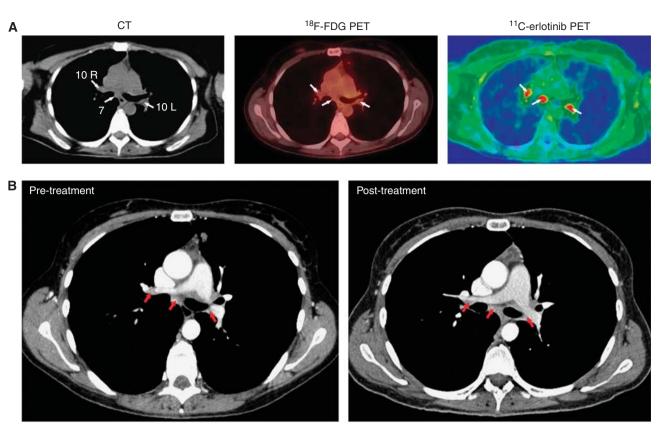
¹¹C-erlotinib accumulation in lymph nodes that were negative on ¹⁸F-FDG PET/CT in a 42-year-old patient (no. 6). (A) Left: transaxial slices of contrast-enhanced CT; middle: ¹⁸F-FDG PET/low-dose CT; right: ¹¹C-erlotinib PET/low-dose CT. CT (left figure) showed an enlarged lymph node (> 10 mm) at position 7 (arrow) and non-enlarged lymph nodes (< 10 mm) at positions 10R and 10L (arrows). None of these lymph nodes were visualized by ¹⁸F-FDG PET/CT (arrows, middle figure), whereas both enlarged and non-enlarged lymph nodes were visualized by ¹¹C-erlotinib PET/CT (arrows, right figure). The ratio between ¹¹C-erlotinib average radioactivity concentrations in the lymph nodes and that in surrounding lung tissue was 2. (B) Comparison of pre-treatment and 1-year post-treatment CT scans showed no significant change in the size of any of these lymph nodes.
